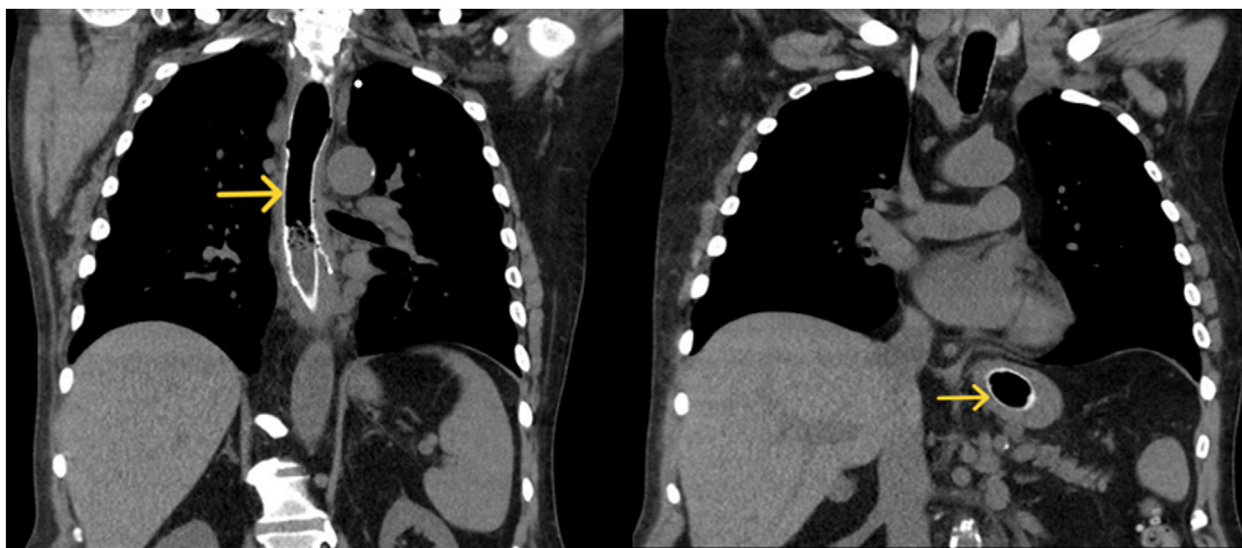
CT scan at 2 months' follow-up showing patent fully covered self-expandable metal stent from the esophagus to the gastric body (yellow arrows).
